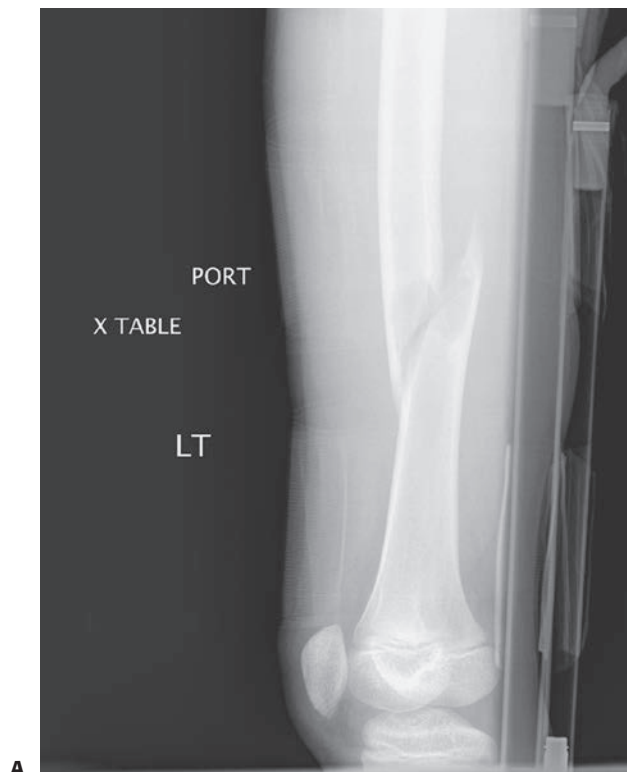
Titanium elastic nailing of the midshaft femur fracture through a benign lytic defect. A: Portable radiograph of a short oblique femur fracture through a benign lytic defect. B: AP radiograph taken several weeks after surgery that show the fracture well aligned with titanium elastic nail internal fixation and early callus at the fracture site.
